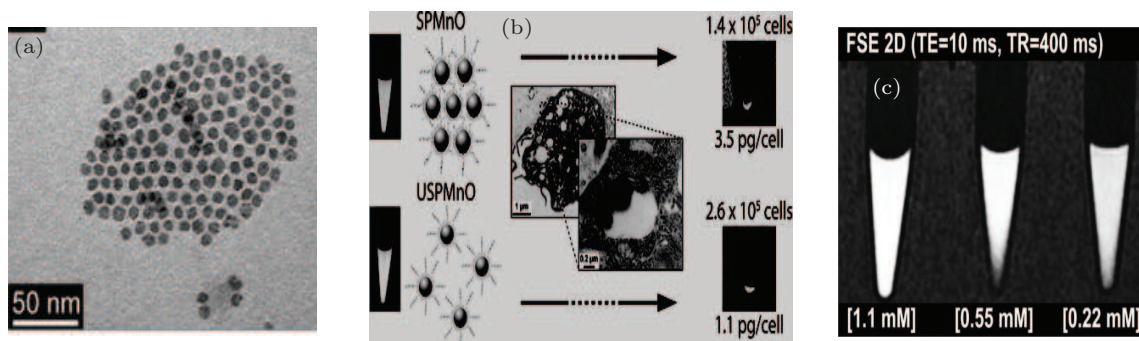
(a) and (b) TEM image and modeling (120 keV) of mono-disperse MnO particles used for relaxometric and cell labeling studies. (c) Dilutions of DMSA-PEG-coated SPMnO, imaged with a T_1 -weighted MRI spin-echo sequence.^[140]
